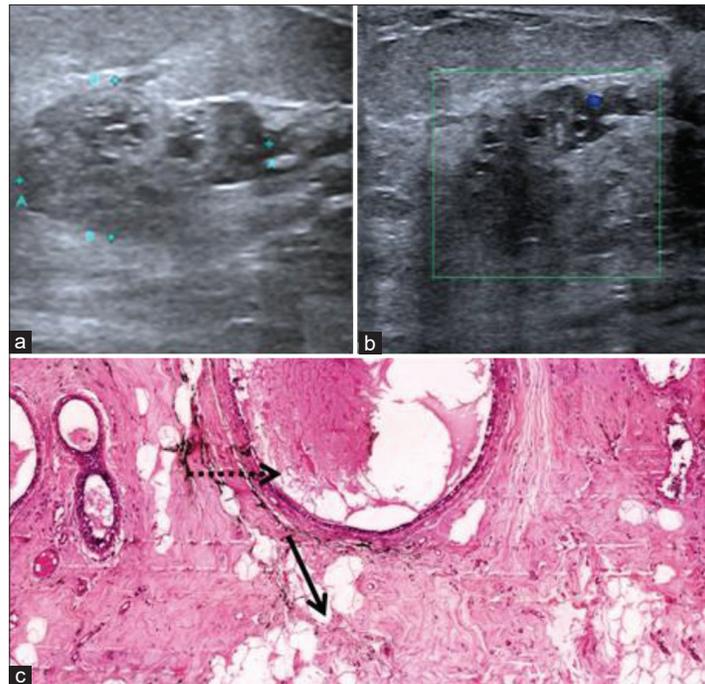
A 35-year-old female with no complaints came for a regular checkup. No history of trauma. (a and b) Ultrasound and color Doppler image shows an irregular hypoechoic mass with tiny cystic changes with absent vascularity and no obvious posterior features (arrow). (c) H & E: Dilated ducts (dotted arrow) and adjacent fat necrosis (black arrow) x200
